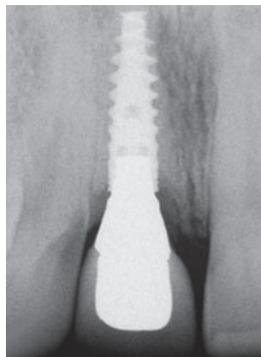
Periapical radiograph of the definitive restoration at 24 months.
